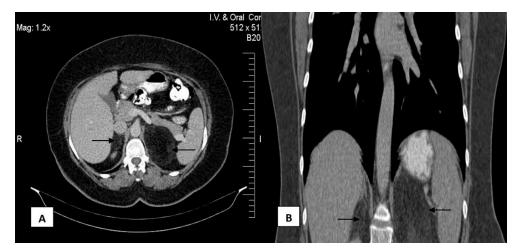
CT scan. (A) The cross-sectional CT scan shows bilateral lesions of the surrounded left and right renal with  $77 \times 63$  mm and  $55 \times 40$  mm, respectively. (B) The coronal-sectional CT scan
